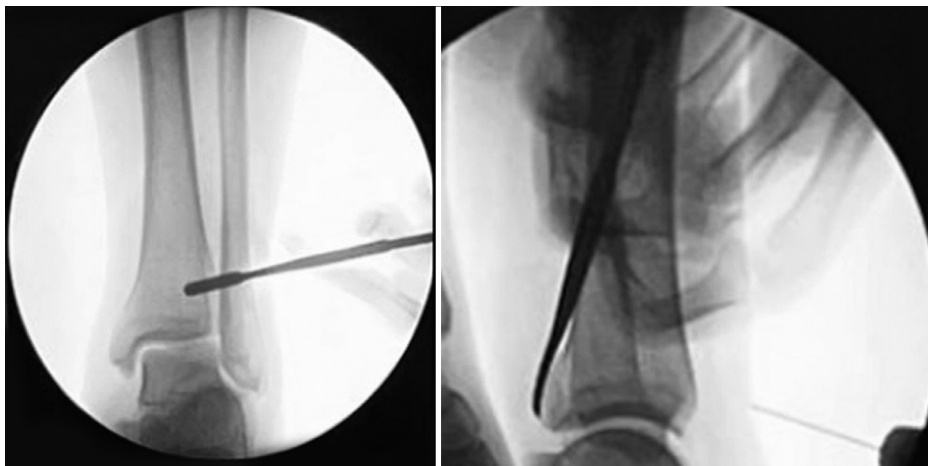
Anteroposterior and lateral ankle radiographs with a periosteal elevator holding the posterior malleolus through a lateral approach.
